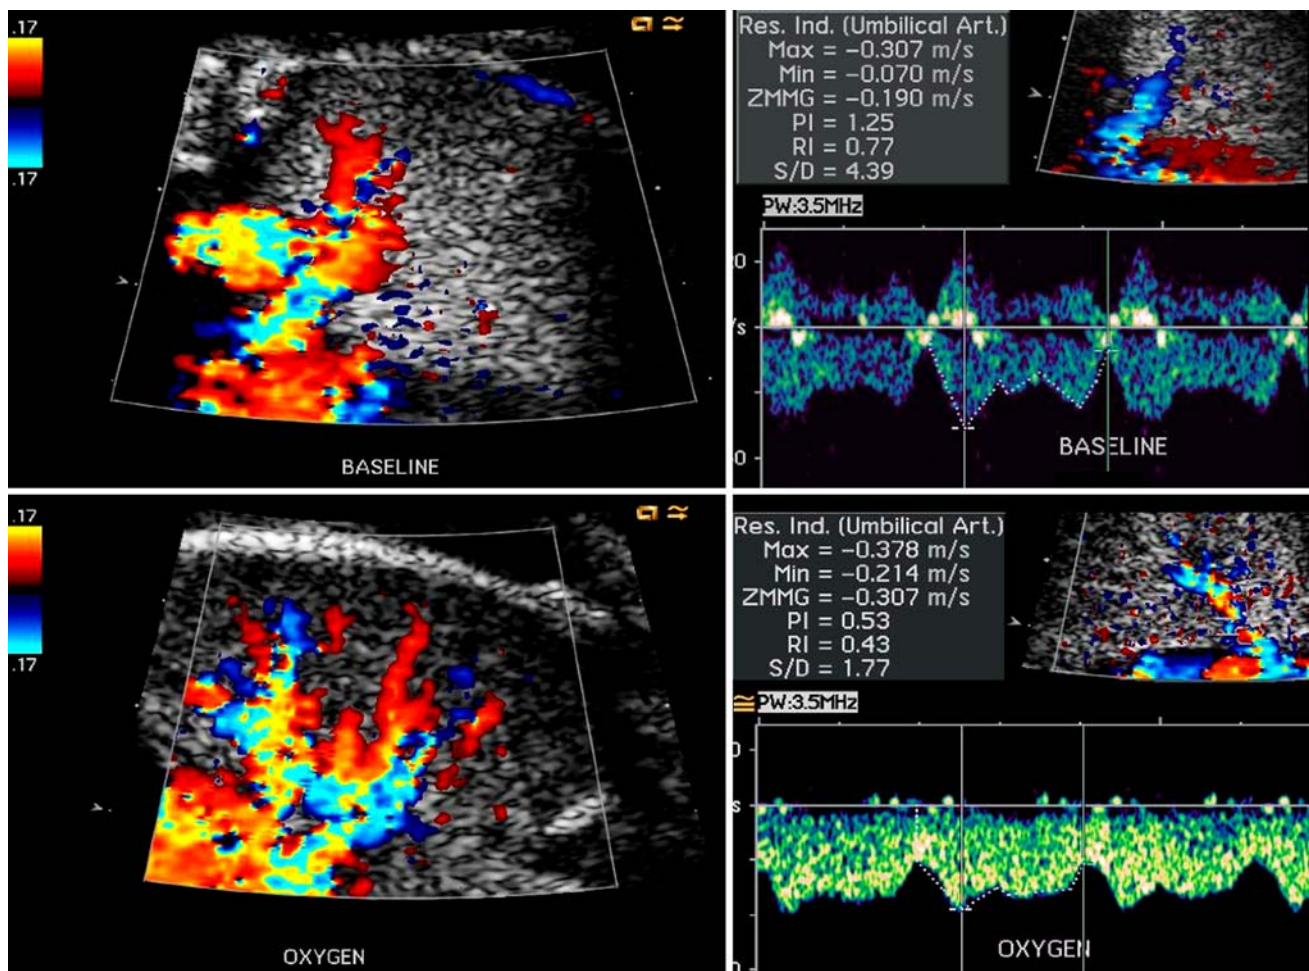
Typical effect of materno-fetal HO on fetal lung blood flow as demonstrated by color and pulsed Doppler echocardiography in a fetus with hypoplasia of left heart cardiovascular structures. Within minutes of initiating treatment, materno-fetal HO results in marked
